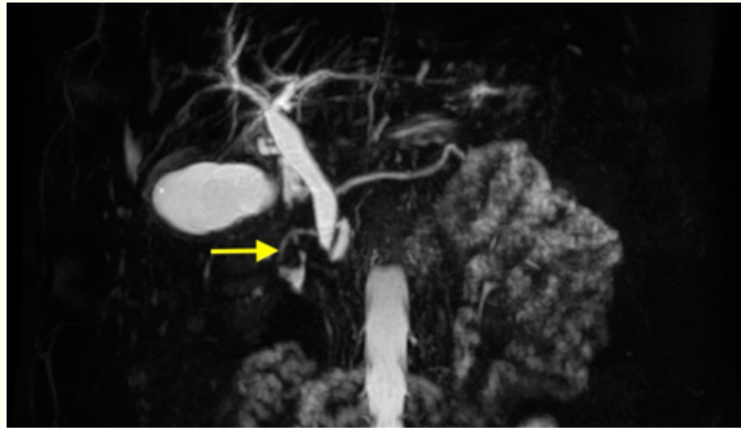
3D Biliary MRI sequence with Maximum Intensity Projection (MIP). The yellow arrow points to a secondary pancreatic duct forming a loop, characteristic of annular pancreas, before draining into the ampulla of Vater.
